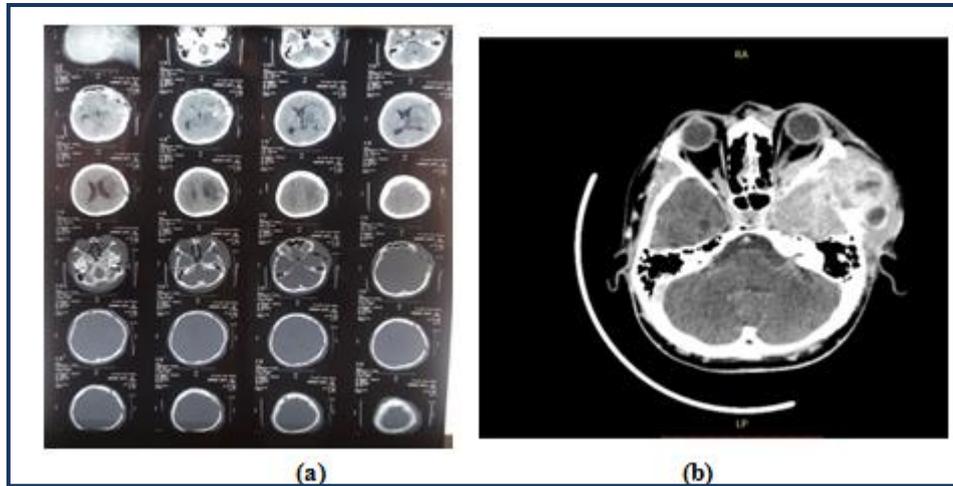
(a) The Second Patient's CT Scan Without Contrast Results (b) Contrastless CT Scan Results of The Second Patient
